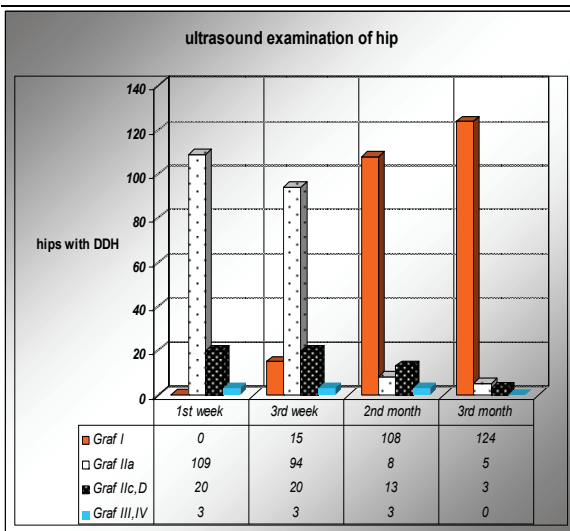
results of serial ultrasonography of the hip
